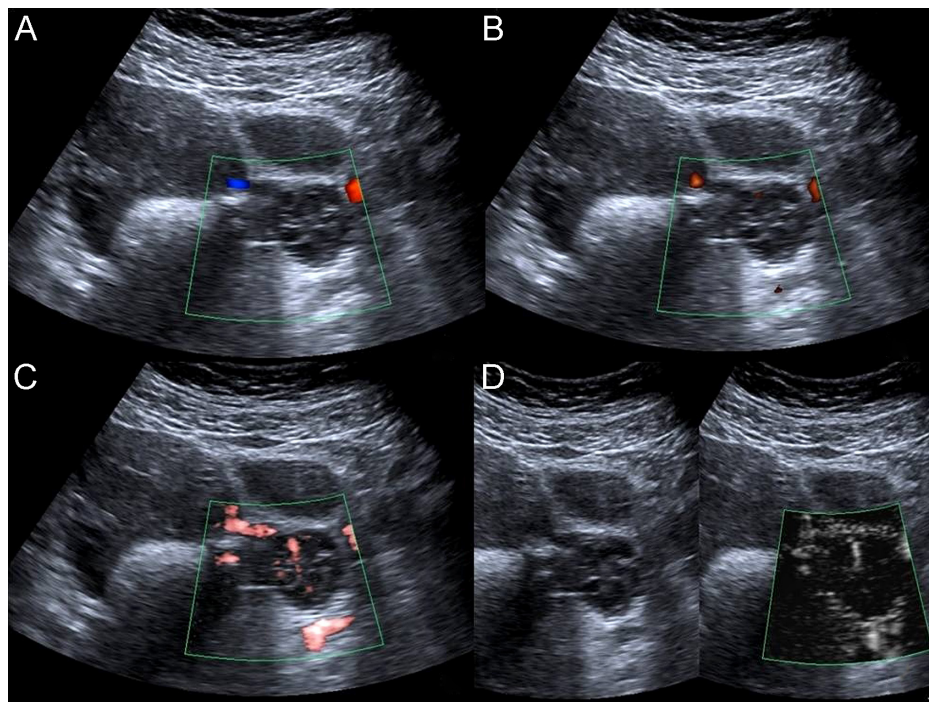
Imaging of a 12-year-old postpubertal girl. There is no vascularity with color Doppler imaging graded as 0 (A). There is one punctate vascularity with power Doppler imaging graded as 1 (B). There are one linear and several punctate vascularities with cSMI graded as 3 (C). There is one linear vascularity with mSMI graded as 3 (D).
